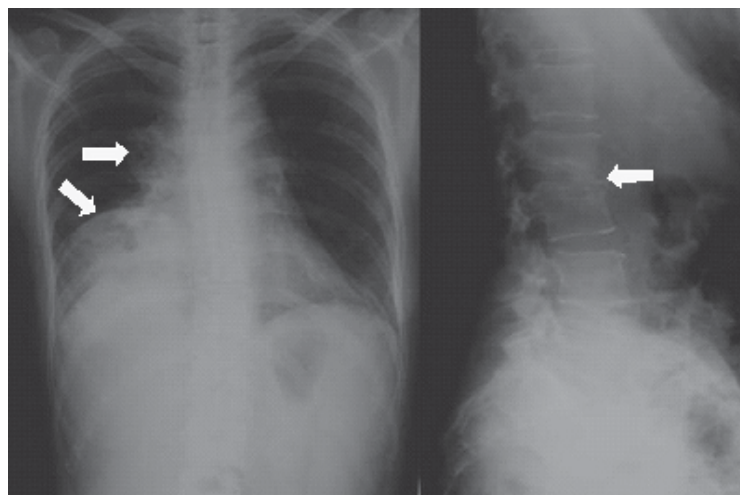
Radiography of the chest and lumbar spine in the presented patient at admission.
